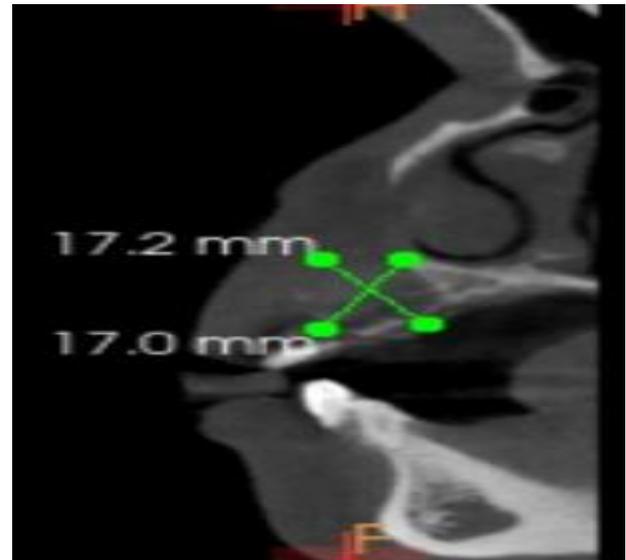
Measurement of the lytic lesion of CBCT Scan.
